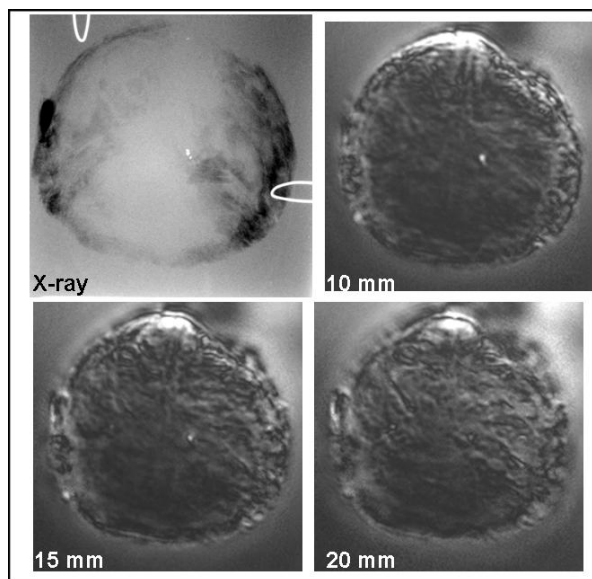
X-ray and VA images of a prostate at different depths are shown. Calcification is noted in all images.
